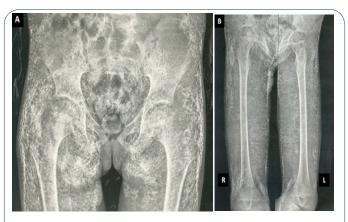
Lower limb radiography showing massive and extensive calcifications of soft tissue.
